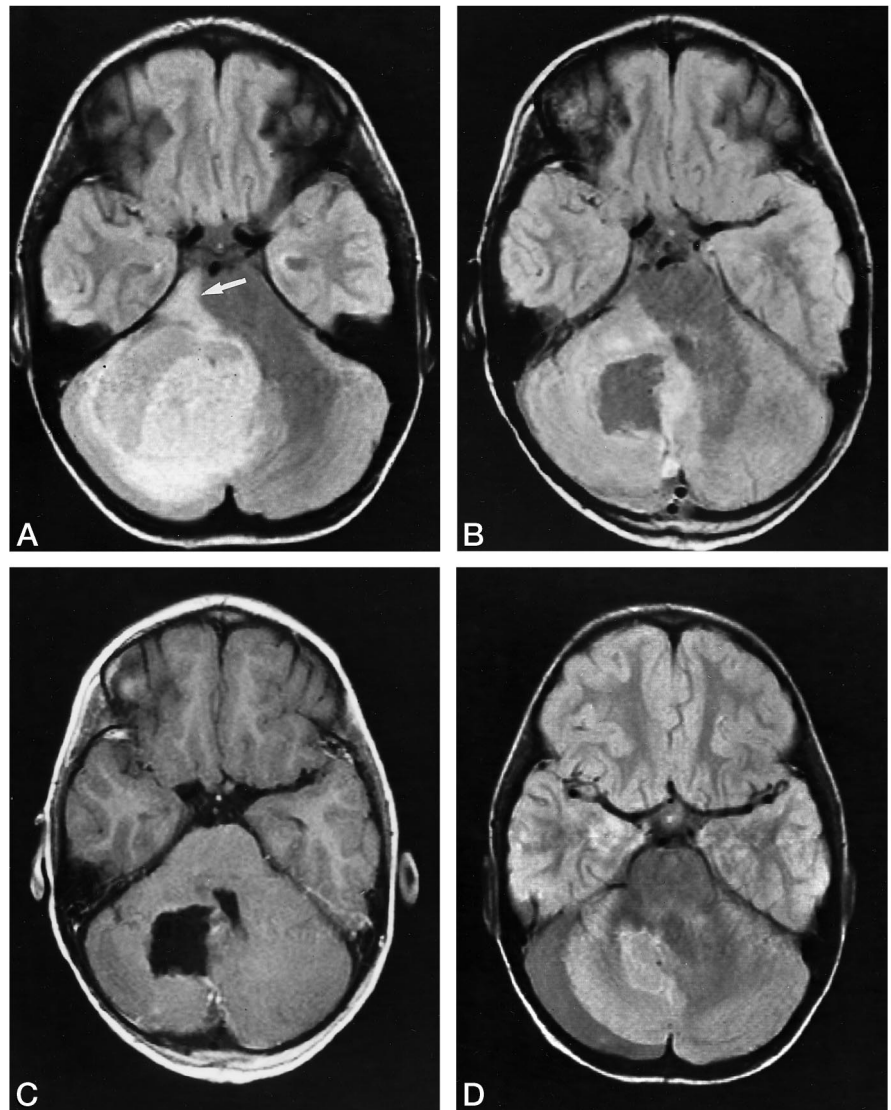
A 4-year-old boy with right cerebellar JPA in whom abnormal T2 signal mimicked residual tumor on perioperative MR images. In this case, absence of significant enhancement on the postoperative MR study was an accurate indication of total tumor resection.
